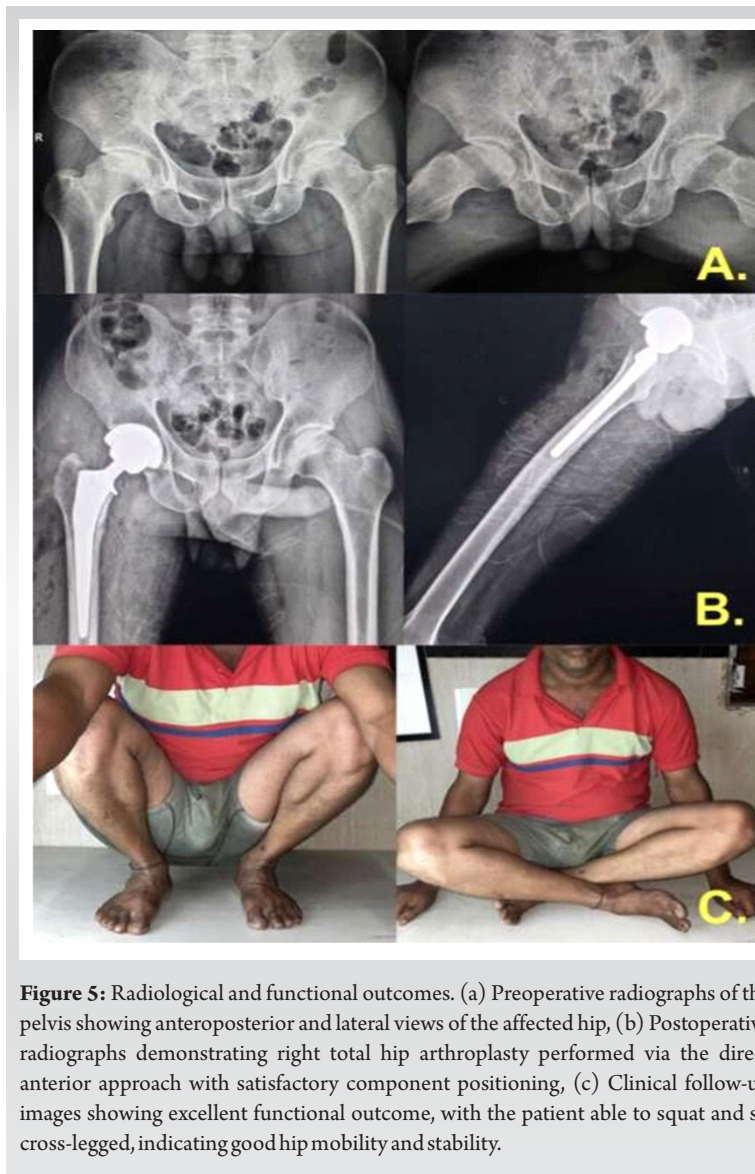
Radiological and functional outcomes. (a) Preoperative radiographs of the pelvis showing anteroposterior and lateral views of the affected hip, (b) Postoperative radiographs demonstrating right total hip arthroplasty performed via the direct anterior approach with satisfactory component positioning, (c) Clinical follow-up images showing excellent functional outcome, with the patient able to squat and sit cross-legged, indicating good hip mobility and stability.
